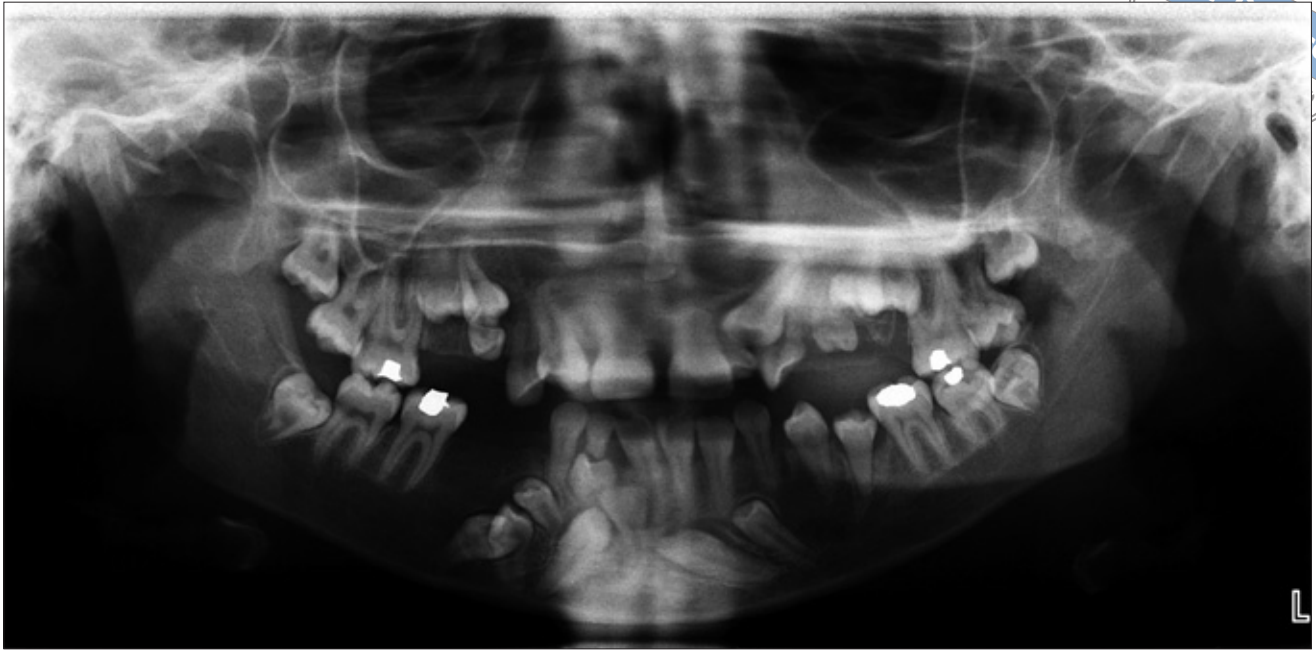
Panoramic radiograph showing the presence of impacted teeth, some of which are supernumerary teeth.
